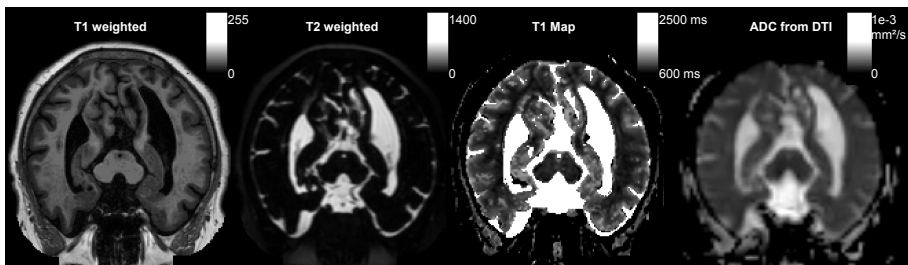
Coronal slices from MRI of a patient from [159] obtained with different MRI modalities.
